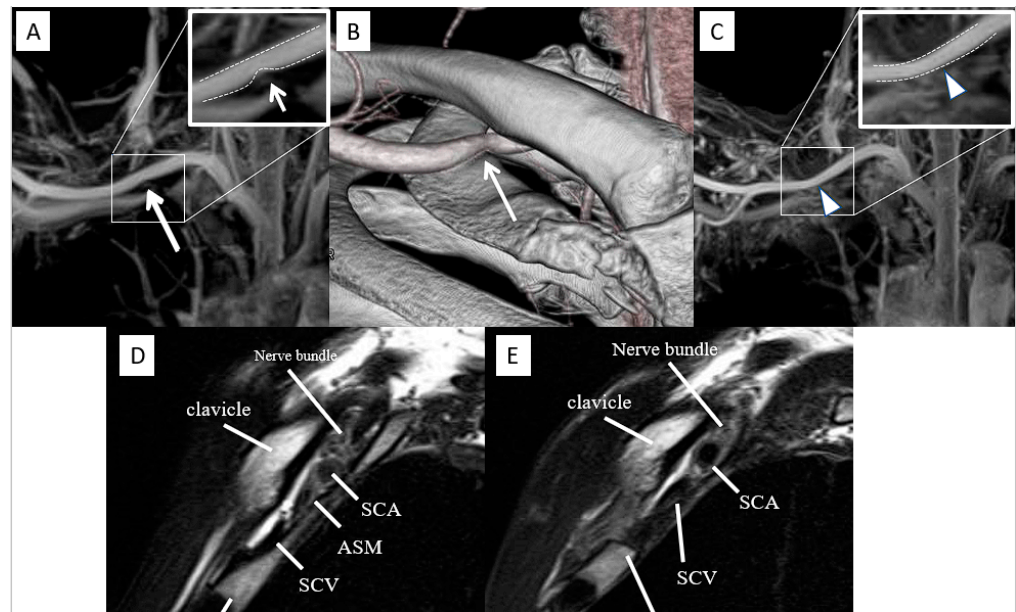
Preoperative and postoperative images. (A) Preoperative MRI-MIP image showing grade 1 stenosis of the SCA (arrow). (B) Preoperative 3D-CT angiography showing stenosis from below at the site where the SCA meets the clavicle (arrow). (C) Postoperative MRI-MIP image revealing stenosis of SCA disappeared and identified as grade 0 (arrowhead). (D) Preoperative sagittal view shows that the anterior scalene muscle is in contact with the SCA, and the SCV is disrupted. (E) Postoperative sagittal view shows that the first rib was resected, and the anterior scalene muscle, which was in contact with the SCA, was absent. Stenosis of the SCV remained. MRI-MIP, magnetic resonance imaging maximum-intensity projection; SCA, subclavian artery; SCV, subclavian vein.
